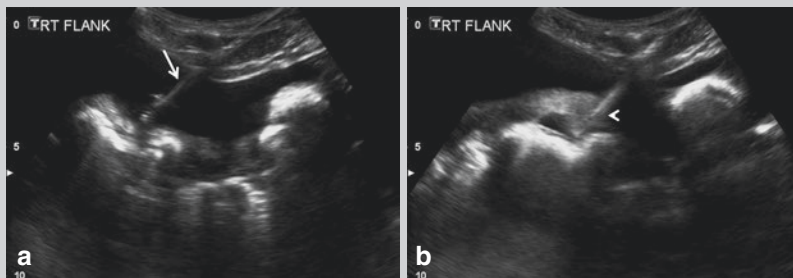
(a) Abdominal ultrasound demonstrating a needle (*arrow*) being passed into the fluid collection under direct imaging guidance. (b) The drain is visualised coiled in the fluid collection (*arrow-head*)
